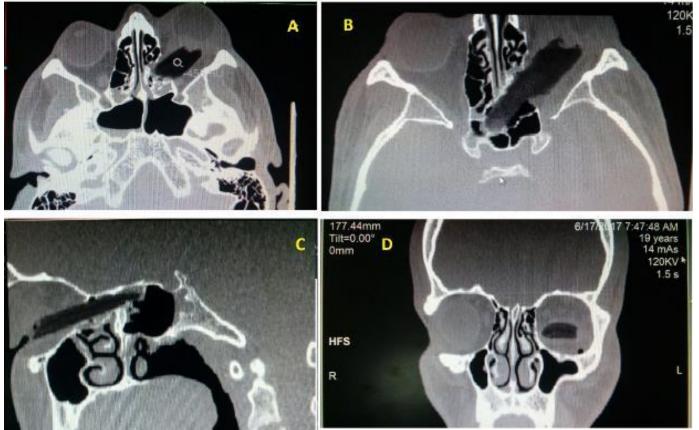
Male patient 19 years old stabbed in Lt orbit by a pointed piece of wood. CT scan was performed; A and B-axial, C- oblique sagittal reformate, and D- coronal reformate. Scans are showing hypodense foreign body (-455 Hu) is seen penetrating the left orbital cavity, displacing Lt eye globe upward and anteriorly (piece of wood). The tip of it is reaching sphenoid sinus.
